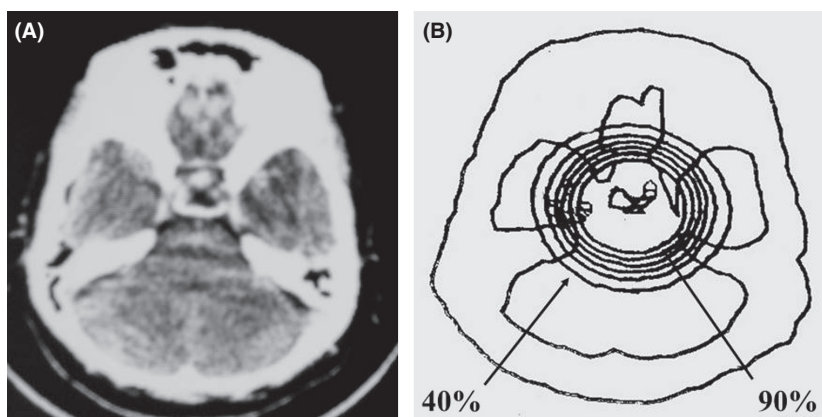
Preirradiation CT (A) and the irradiation field (B).
